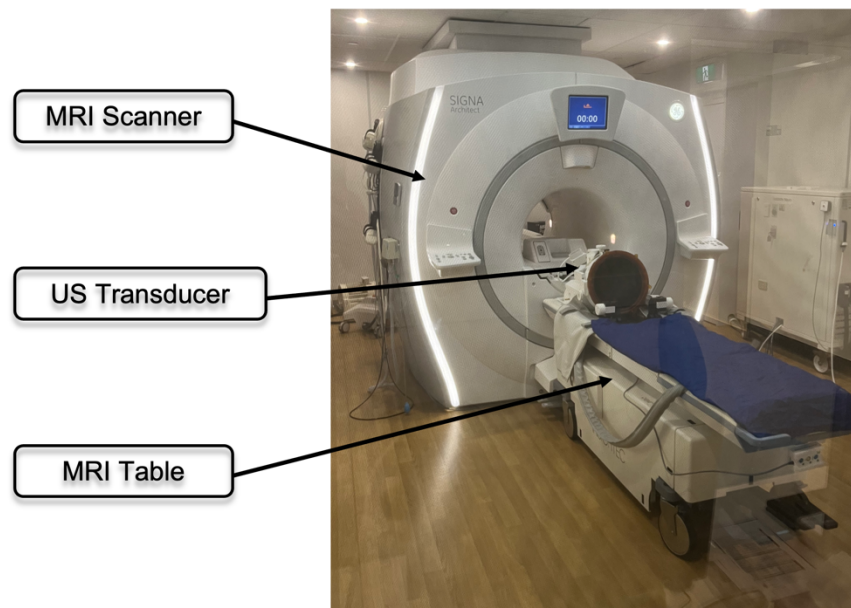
MRI scanner and US transducer. Bottom - Summary of components in tcMRgFUS system. Adapted from (Kyriakou et al. 2014).
